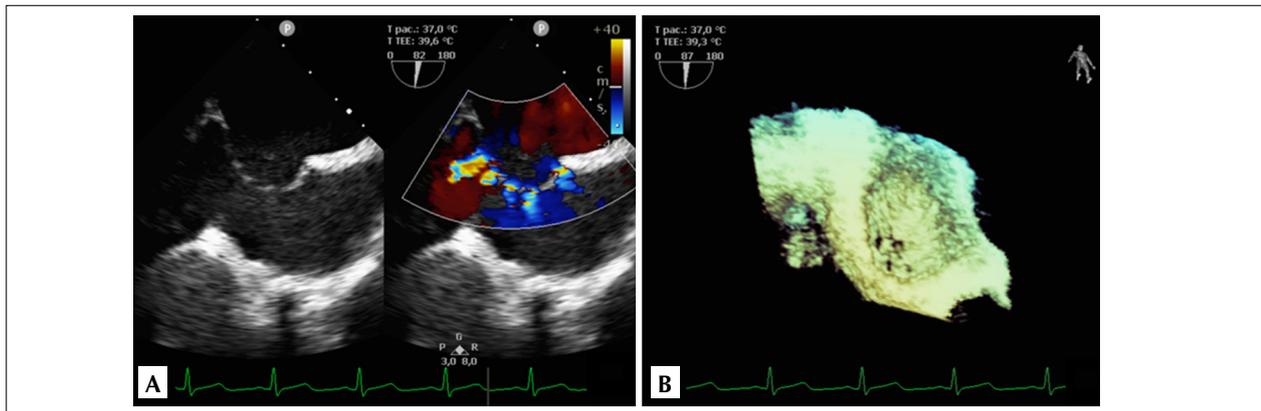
Transthoracic echocardiography pre-percutaneous closure procedure performed on April 6, 2018. A. Two-dimensional image of a multi-fenestrated atrial septal defect (ASD; five fenestrations). B. Three-dimensional image of a multi-fenestrated ASD.
